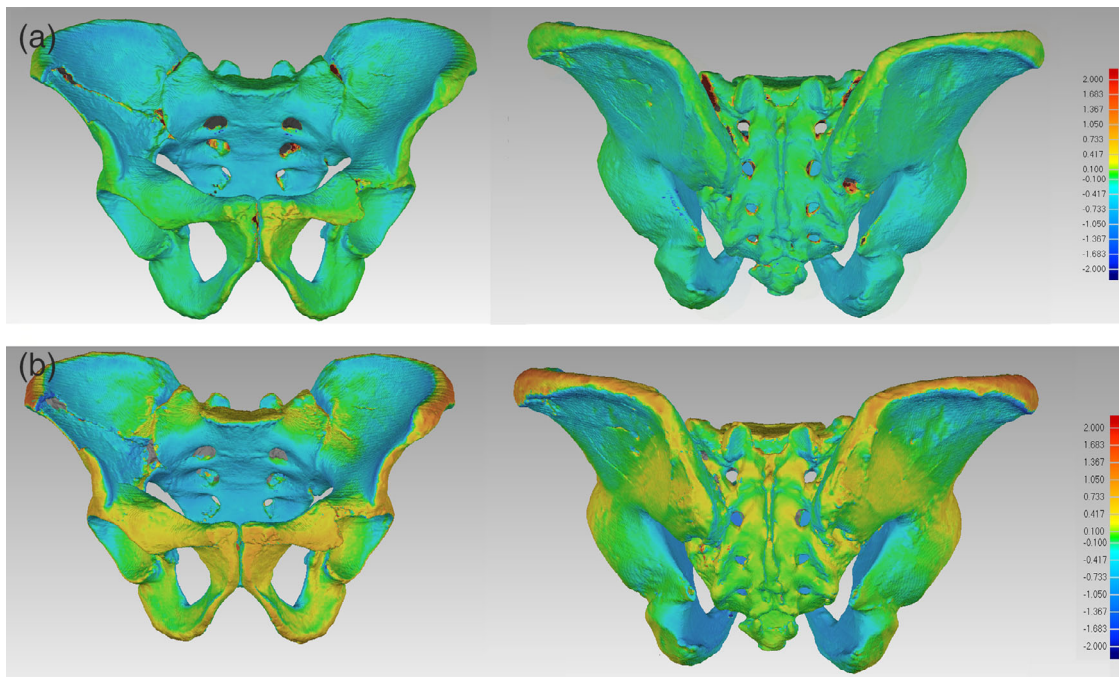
(a) Differences between the pelvic surfaces extracted from a clinical CT scan and photogrammetry, visualized as a color map. (b) Differences between the pelvic surfaces extracted from a clinical scan and 3D structured light scanner. A positive deviation indicates that the mesh obtained by surface scanning or photogrammetry is larger than the mesh obtained by CT scanning (yellow to red colored areas). In areas with a negative deviation, the photogrammetric or surface scanned mesh is smaller than the reference mesh of CT scanning (blue). If the surface differences were smaller than 100 μm, we defined these differences as non-relevant deviations between the methods. (green areas)
